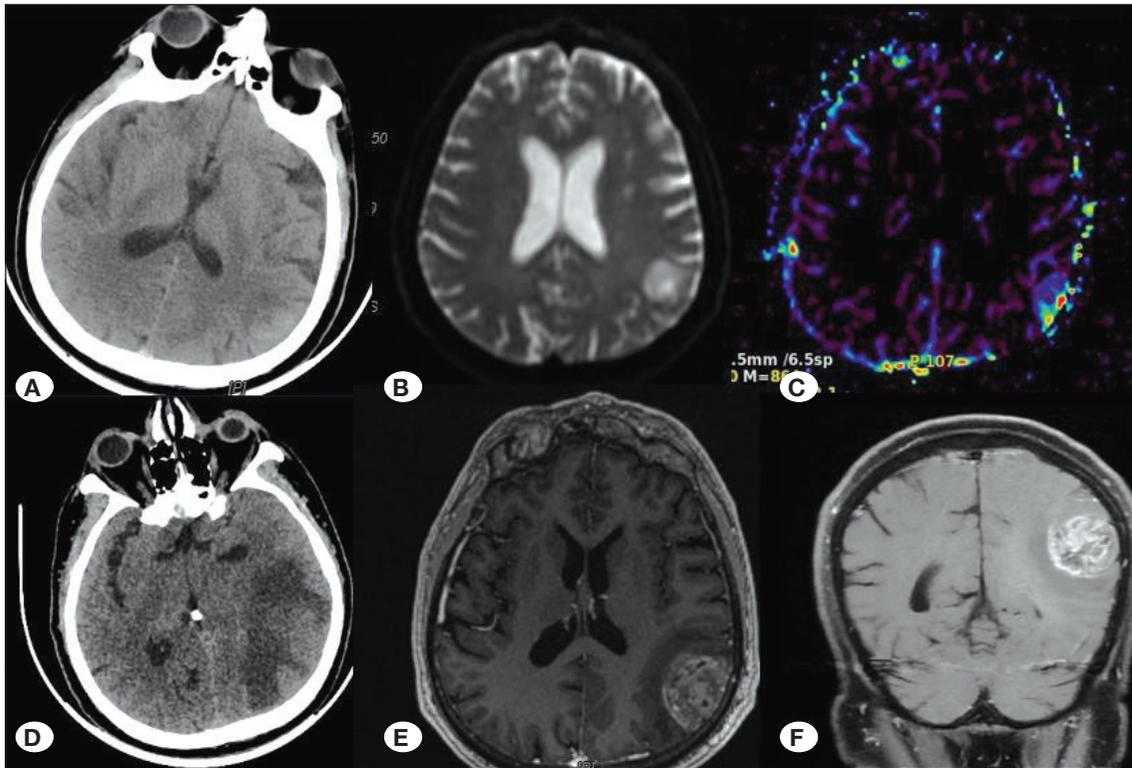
A) Axial section CCT, B) axial section diffusion MRI, C) axial section perfusion weighted brain MRI. D) 1st month axial section CCT, E) 1st contrast enhanced T1W axial brain MRI, F) 1st month contrast enhanced T1W coronal brain MRI.
